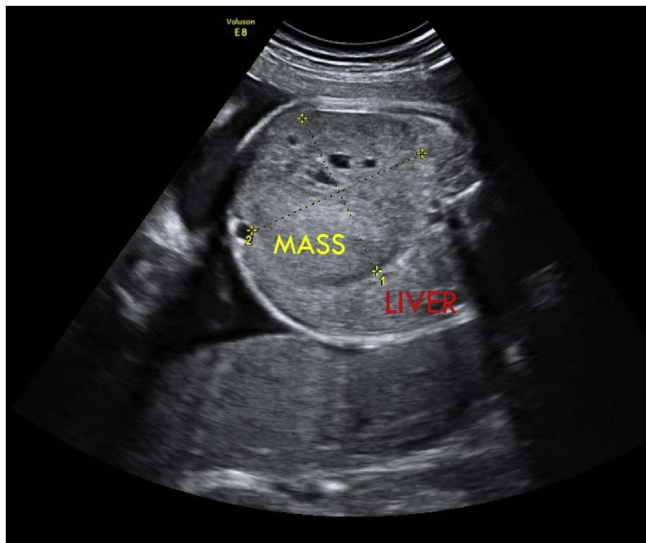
Prenatal ultrasound demonstrated polyhydramnios and a large abdominal mass occupying almost the entire abdomen.
